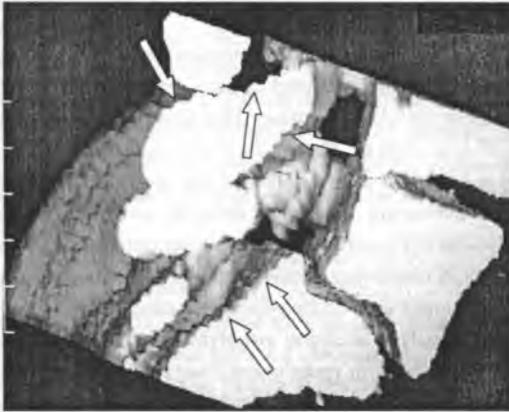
Stair step artifacts (arrows) on 3D CT spine reformation
